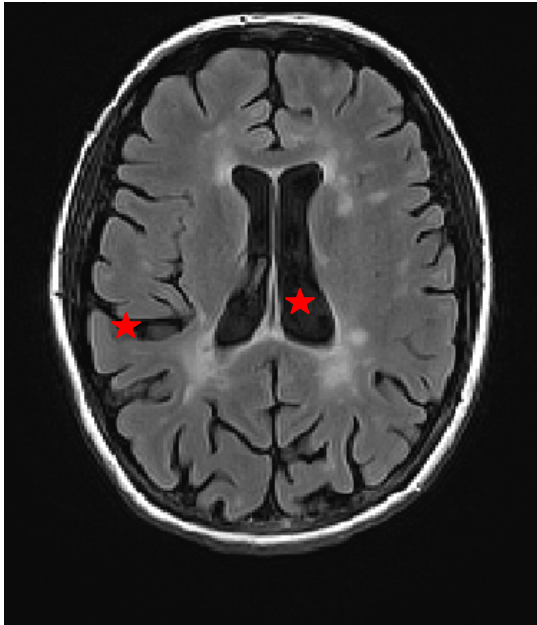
Typical hyperintense partly confluent lesions adjacent to the ventricles on this FLAIR sequence in a 25 year old female patient with an active RRMS. Notice the widening of ventricular and subarachnoid spaces indicating brain volume loss (red star)
